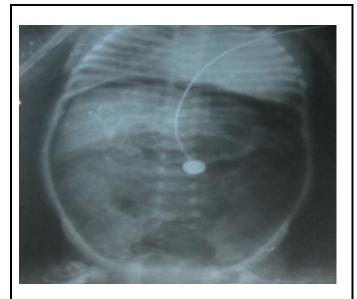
Straight X-ray abdomen and pelvis shows free gas under the diaphragm and huge pneumoperitoneum following an episode of pneumonitis in a known patient of congenital heart disease (VSD).
